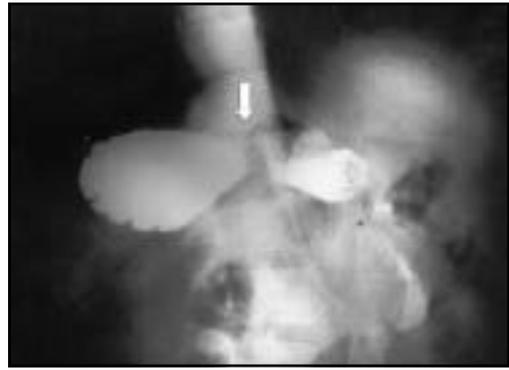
Plain abdominal x-ray showed a partial small bowel obstruction with a narrow segment.
